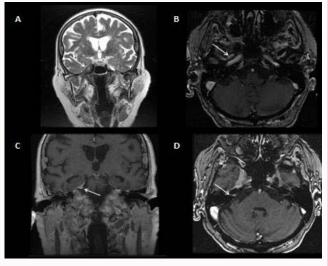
A) MRI coronal T2 sequence showing the obliteration of Meckel's cave (white arrow) by tumor. B) MRI axial T2 sequence highlighting infiltration of foramen rotundum (white arrow) by tumor. C) MRI coronal gadolinium sequence highlight enhancement of CN V (white arrow) as it exits the pons. D) MRI axial gadolinium sequence depicting the small nodular mass (white arrow) arising from CN VII.
